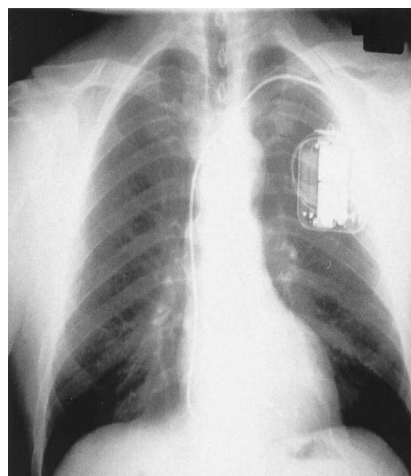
Implanted ICD as seen by chest x-ray.
